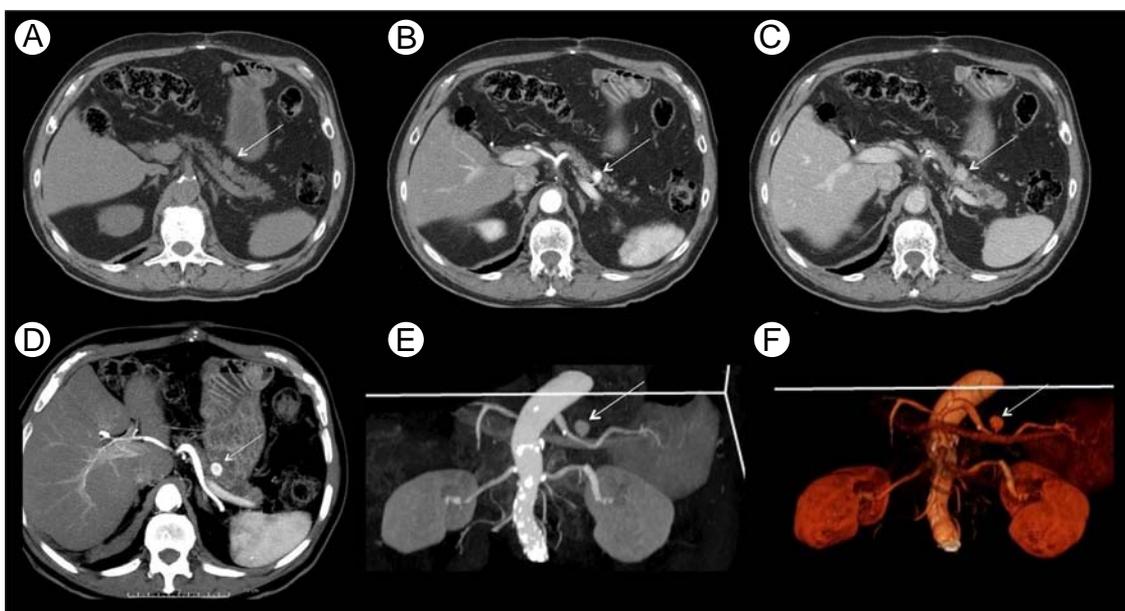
Intrapancreatic true arterial aneurysm mimicking hypervascular pancreatic tumor in an 81-year-old man. Unenhanced (A), arterial (B), and portal (C) CT axial images reveal a 1.8-cm aneurysm arising from an arterial branch of the mid portion of the splenic artery (arrows). The aneurysm appears well defined and homogeneous, with a central thrombus on axial maximum intensity projection (MIP) reformation (D) (arrow). 3D angiographic MIP (E) and 3D volume rendering (F) images help to better demonstrate the vascular origin of the lesion (arrows). (Color version of figure is available online.)
